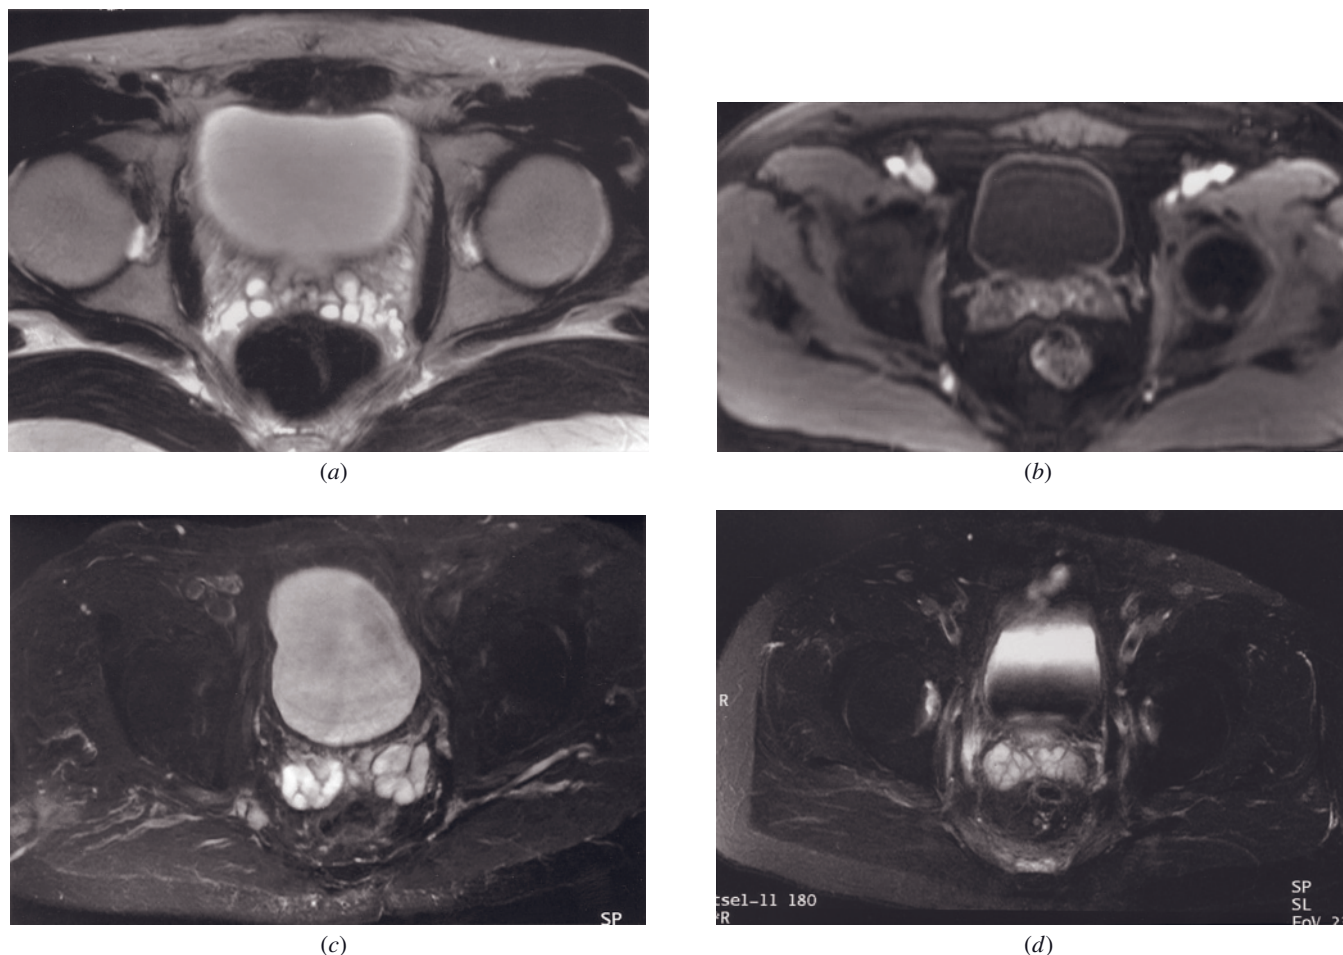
Normal seminal vesicles. Transverse T2-weighted ETSE (a) image. High signal intensity is seen within the normal fluid-filled seminal vesicles on the T2-weighted image (a). Immediate postgadolinium fat-suppressed T1-weighted gradient-echo image (b) in a second patient. Note how fat suppression increases conspicuity of the convoluted walls of the seminal vesicles, which enhance relative to the fluid that they contain (b). Transverse T2-weighted fat-suppressed ETSE image (c) in a third patient. Normal, fluid-filled seminal vesicles exhibit high signal intensity on T2-weighted images. The low signal intensity of the walls of the tubules gives the glands a cluster of grapes appearance. The external borders are clearly demarcated after the application of fat suppression. Transverse T2-weighted fat-suppressed ETSE image (d) in a fourth patient. The seminal vesicles are high in signal intensity on this high-resolution T2-weighted image. Image acquisition after gadolinium administration accounts for the low signal intensity within the dependent portion of the urinary bladder.
